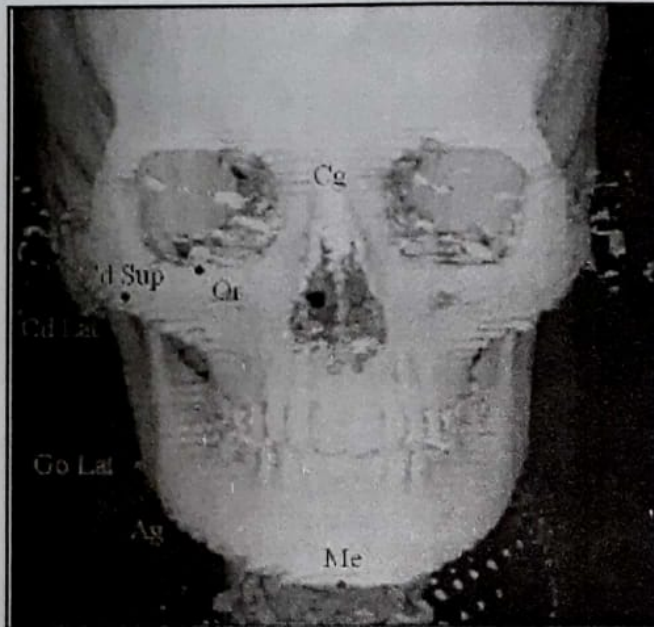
Landmarks used for the assessment of facial asymmetry in the 3D CT image.
